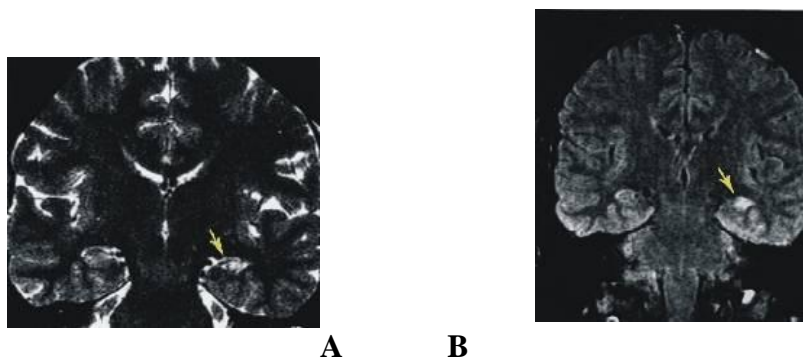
(A) MRI detects mesial temporal sclerosis by demonstrating this size asymmetry and abnormal signal within the atrophied hippocampus. (B) Thin-section high-resolution coronal MR images are best for detecting these abnormalities, which can be subtle.
